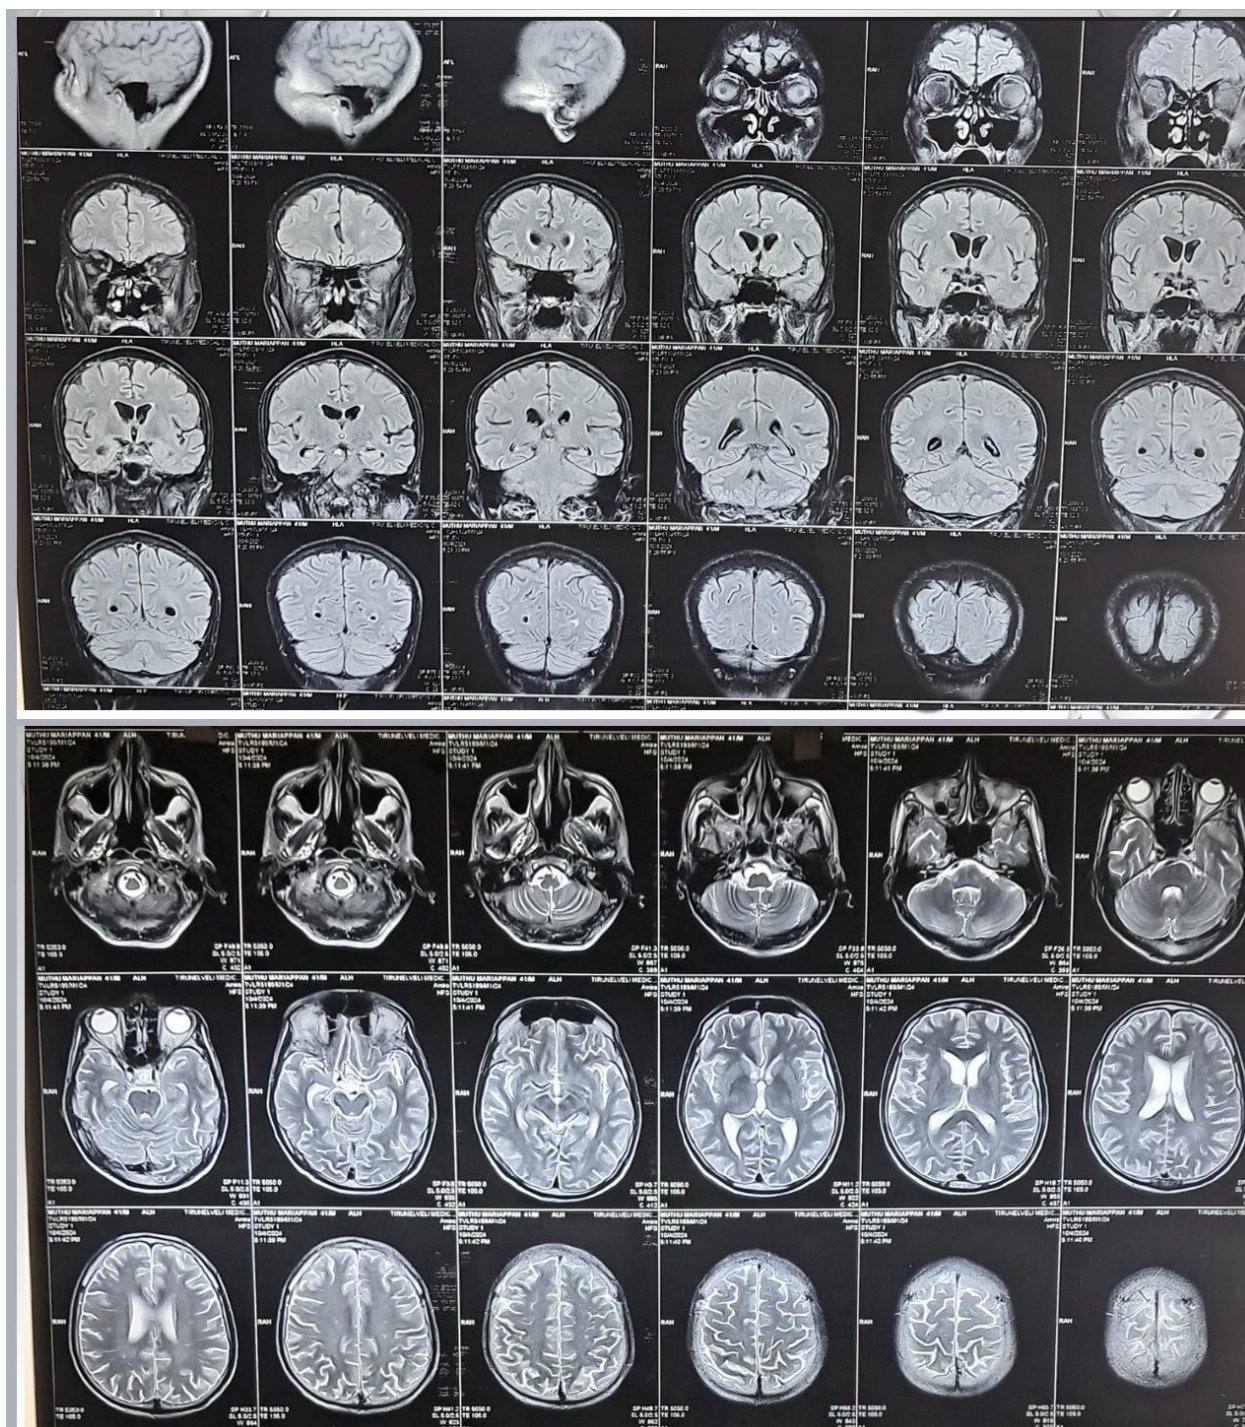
MRI brain showing bilateral multiple small cortical and subcortical infarcts suggestive of cerebral vasculitis.
